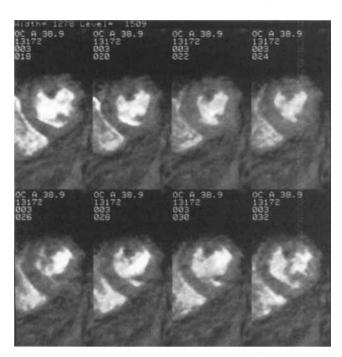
Cine magnetic resonance images of the true short axis of the left ventricle, upper left end-diastole, upper right end-systole, at the level of the papillary muscles. For technique refer to text.
